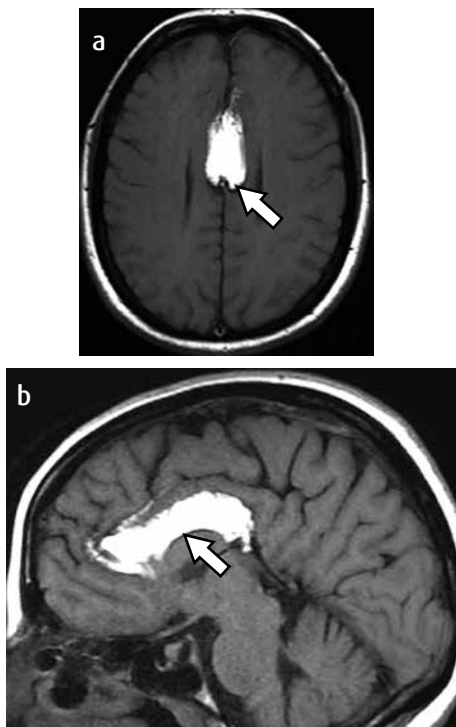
MRI T1-weighted sequence. a) Axial, b) sagittal. High signal image (arrow), localized in the pericallosal sulci towards the anterior region of the corpus callosum compatible with lipoma. It is associated to dysgenesis of the corpus callosum.
